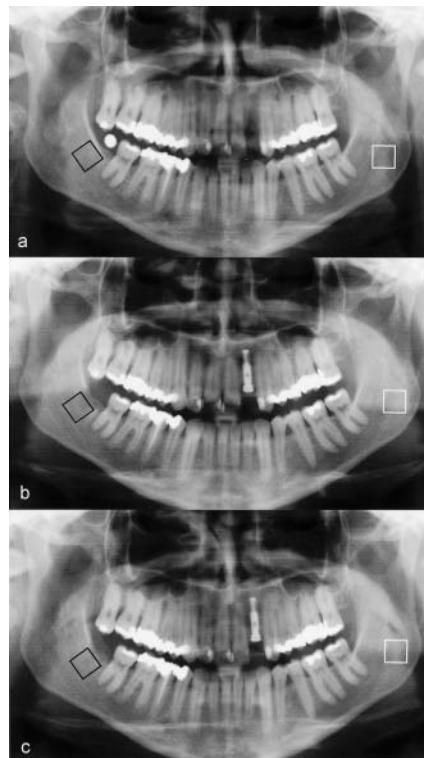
Pre- and postoperative X-rays. a) Preoperative panoramic radiograph with radiological marker *in situ* retromolar left, black rectangle region of interest for densitometric evaluation, white rectangle reference region of interest. b) Panoramic radiograph directly postoperatively. c) Panoramic radiograph 6 months postoperatively.
